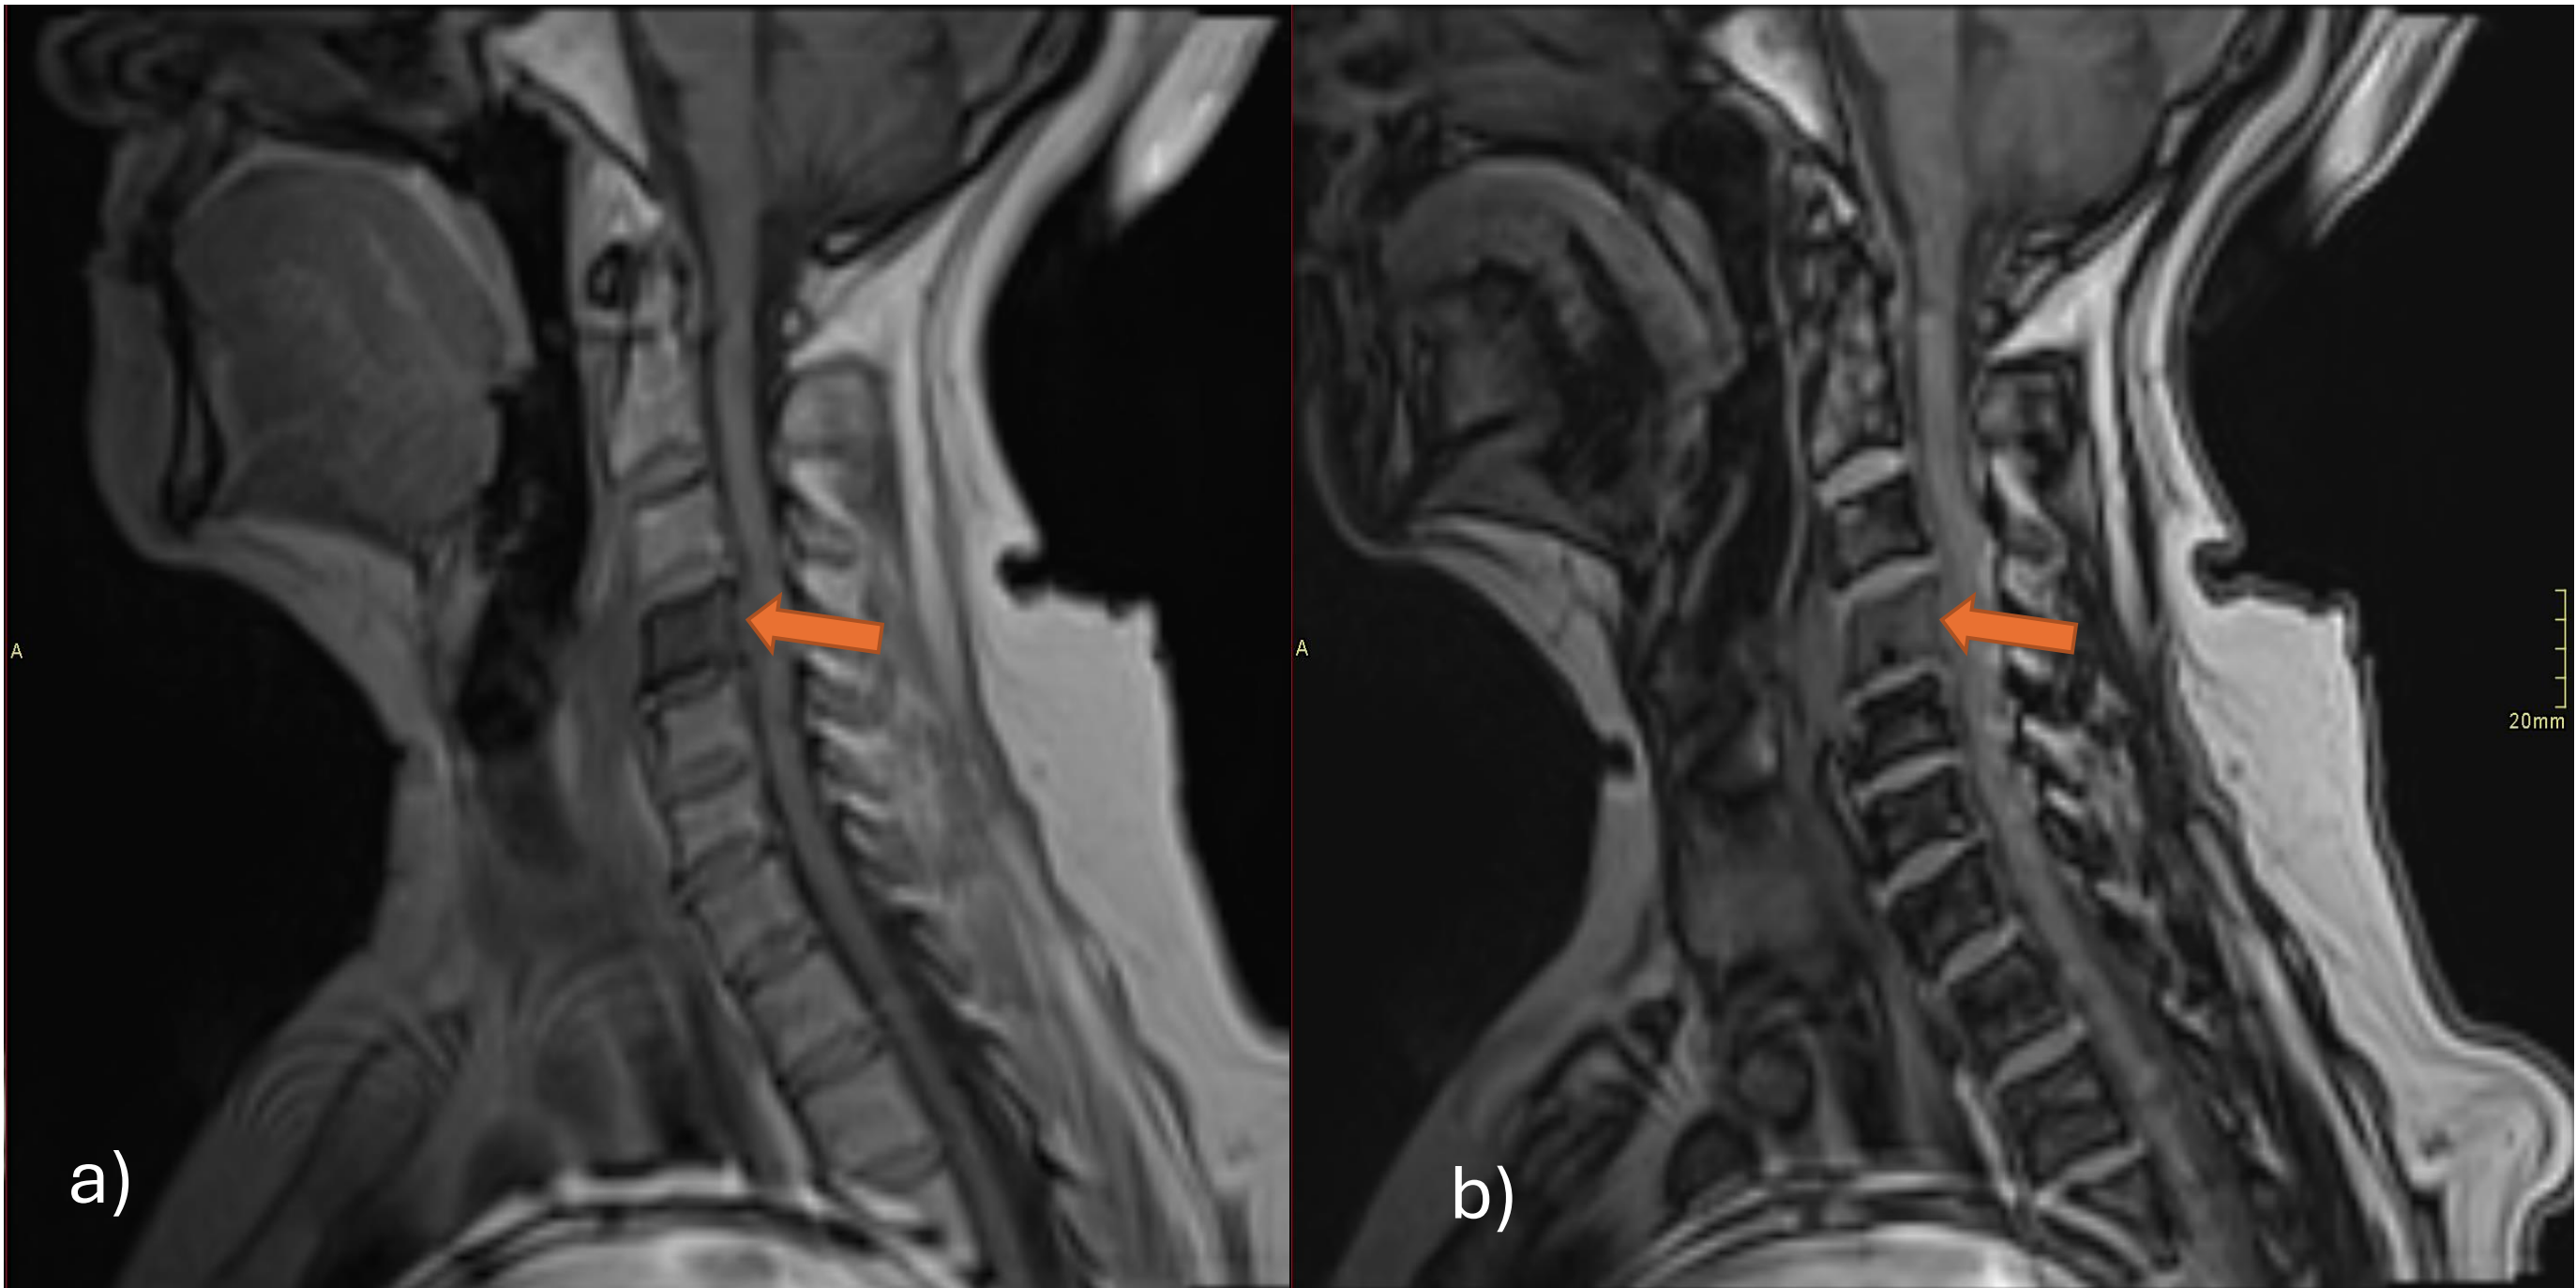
Patient no. 1. Cervical spine MRI using the Dixon technique, sagittal planes. a) In-phase sequence: low signal intensity in the affected vertebral body due to the absence of fat signal. b) Out-of-phase sequence: in the absence of intralesional fat, signal cancellation does not occur, resulting in a hyperintense signal. These abnormal signal characteristics are consistent with malignant infiltration of the bone marrow.
